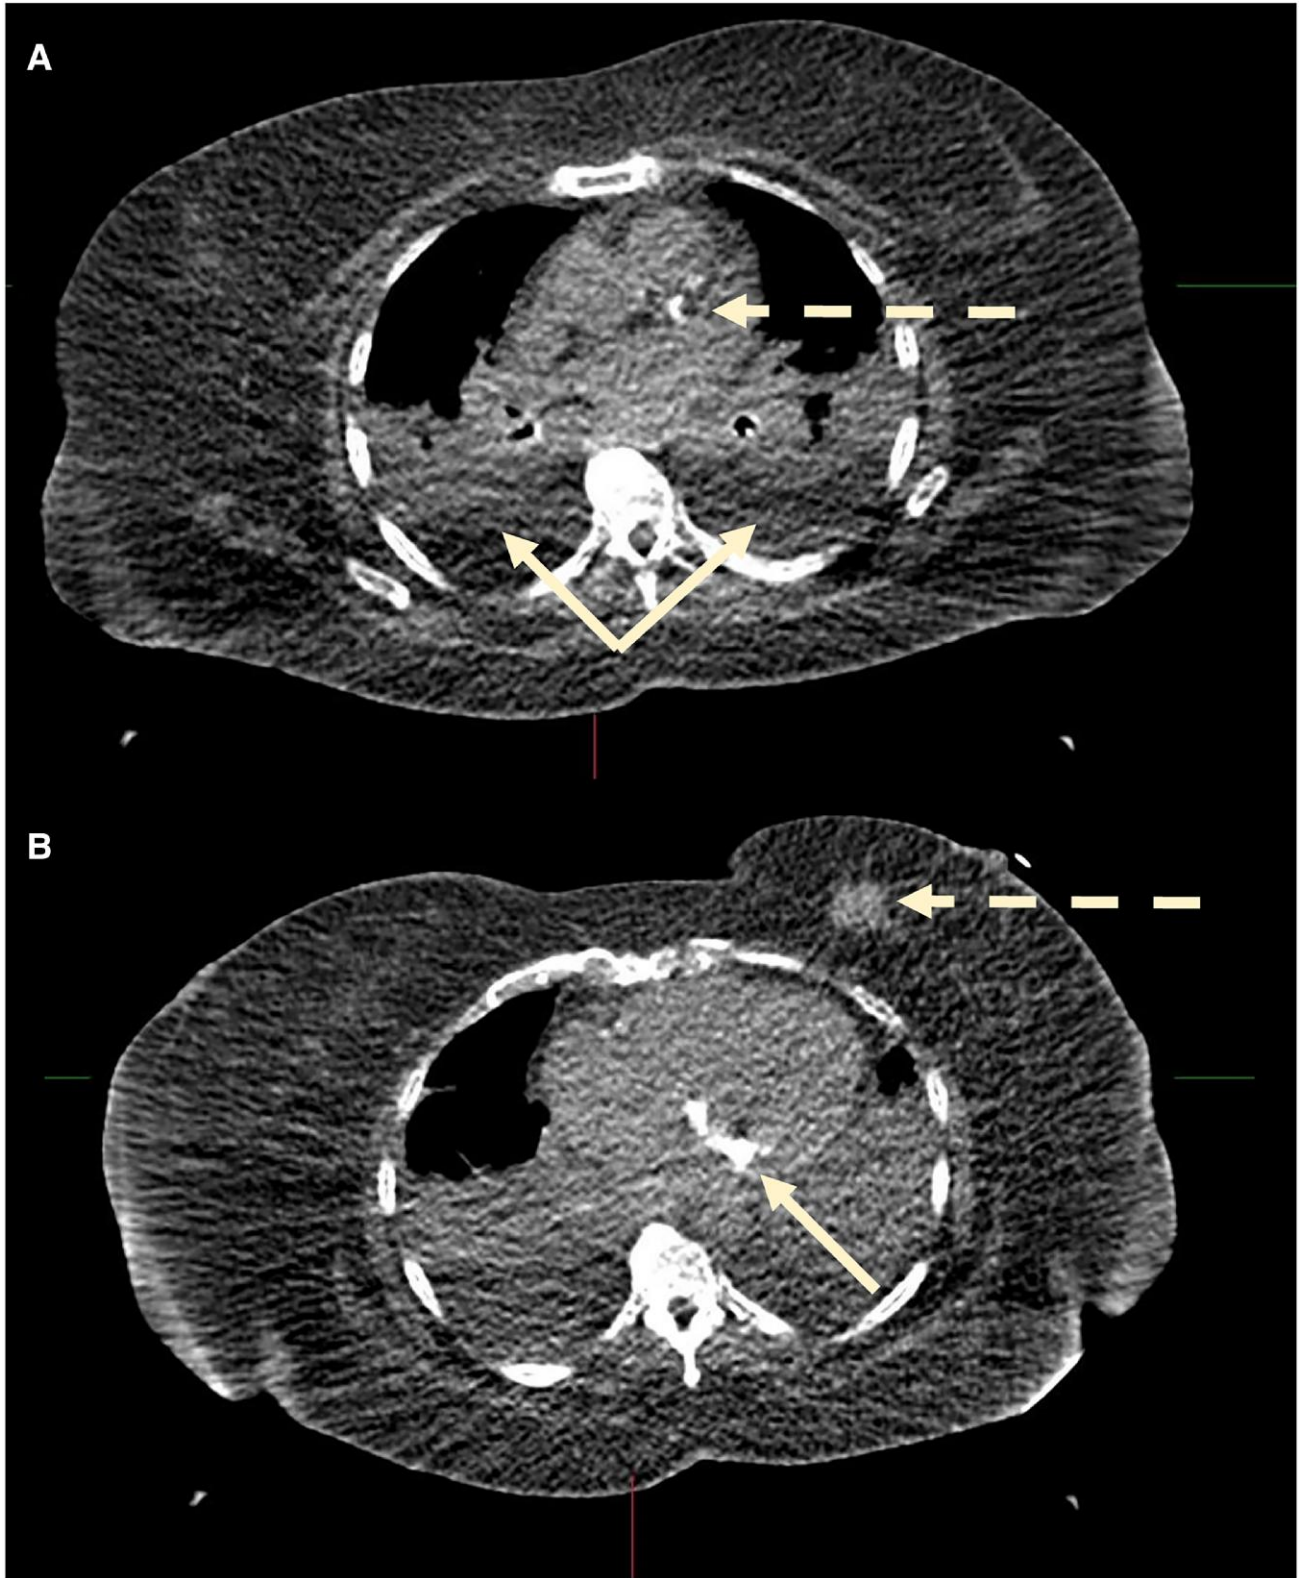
Incidental findings on CT performed for attenuation correction. (A) Coronary artery calcification (dotted line) and bilateral pleural effusions (solid line). (B) Breast mass (dotted line) and severe mitral annular calcification (solid line).
